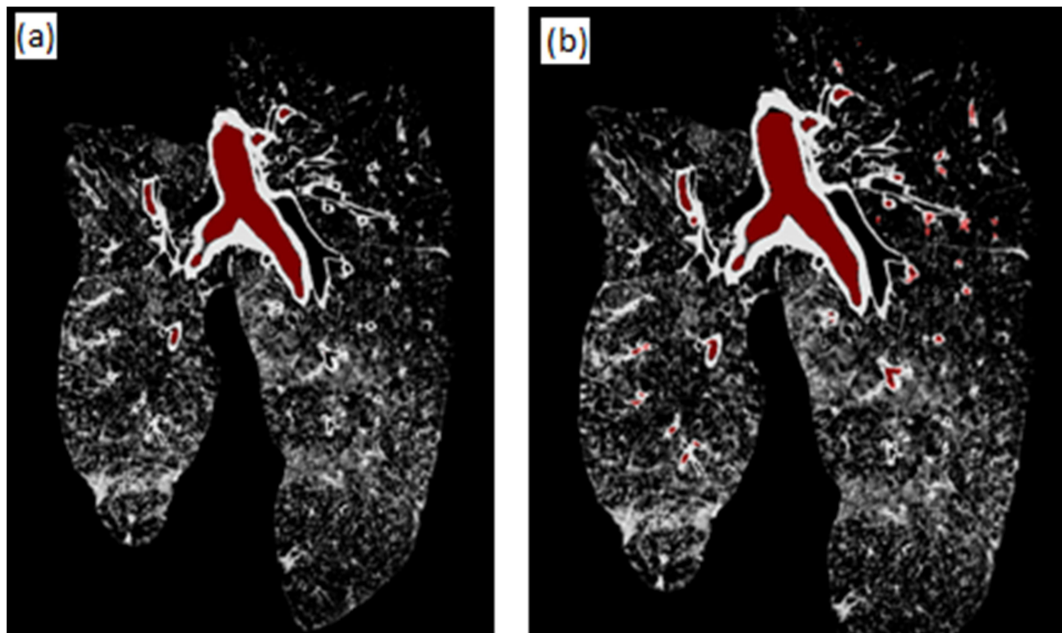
Lung CT images used for segmentation: (a) airway #1, (b) airway #2.
